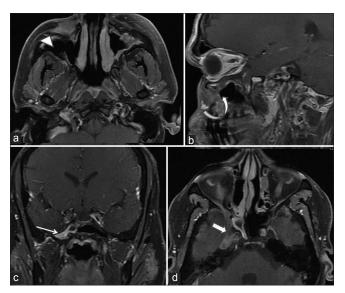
Follow-up images after 2 months. Fat-suppressed contrast-enhanced T1-weighted axial (a) sagittal (b) coronal (c) and axial (d) images show significant reduction of lesion in right premaxillary region (arrowhead), floor of orbit (curved arrow), foramen rotundum (arrow), and Meckel's cave (block arrow)
